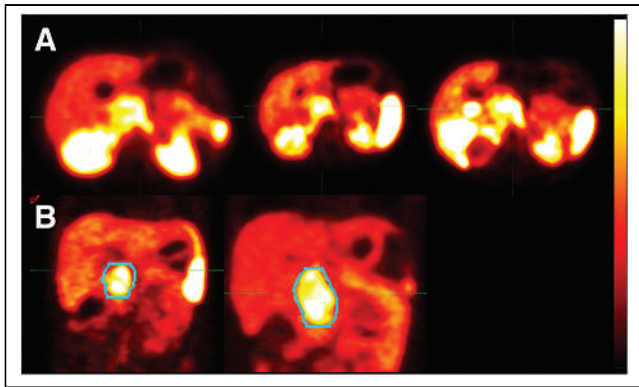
Early progression in primary mass detected on ^{68}Ga -DOTATATE PET/CT, with increase in volume not apparent on correlative MRI because of associated variable signal changes, edema, and necrosis. PET tumor thresholding allows accurate assessment of viable tumor volumes on axial PET images at, from left to right, initial staging, 2 mo, and 6 mo (A) and on coronal PET images at, from left to right, 2 and 6 mo (B).
